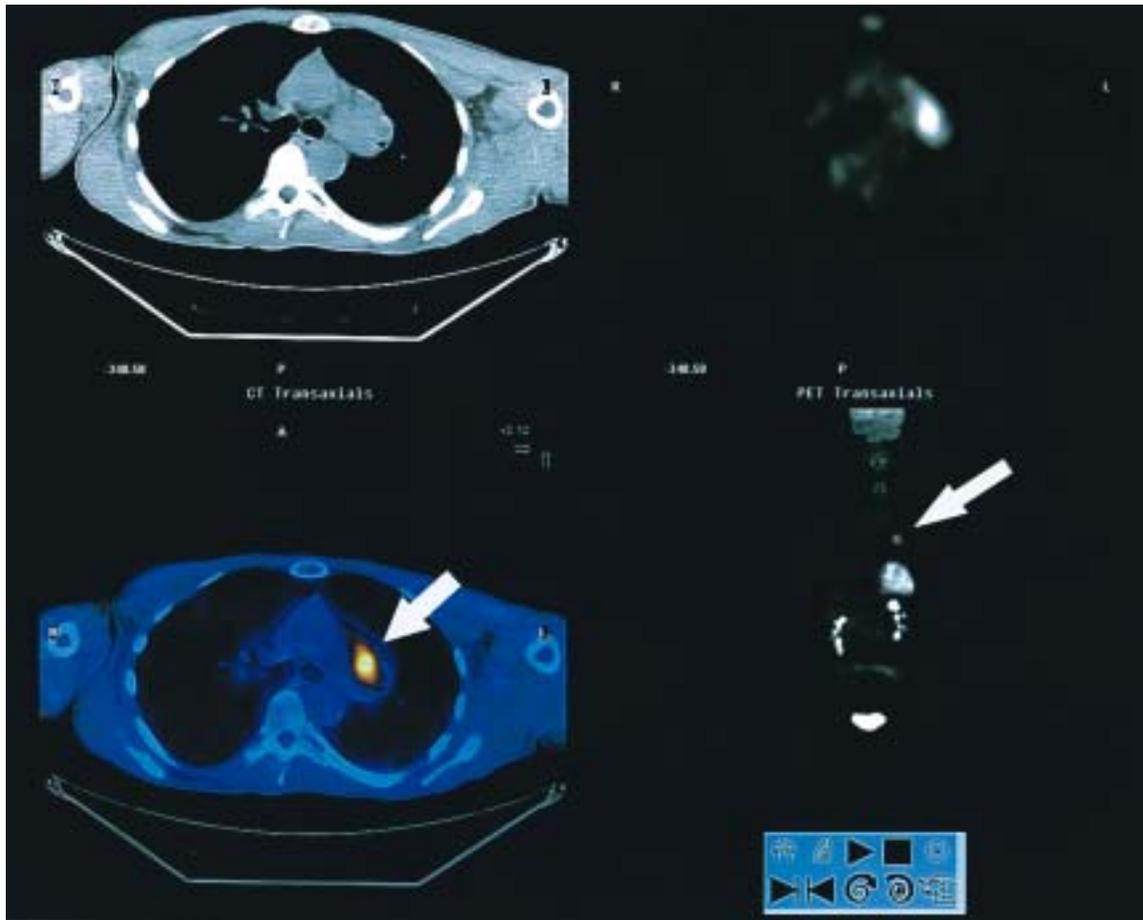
Computed tomogram (CT) (upper left) shows some bulkiness in the left hilar region, with an area of hypermetabolic activity within a large lymph node (arrow) identified on the CT/positron emission tomogram (PET) image fusion (lower left); PET (right) confirms this area (arrow) in the mediastinal region. A = anterior; L = left; P = posterior; R = right.
